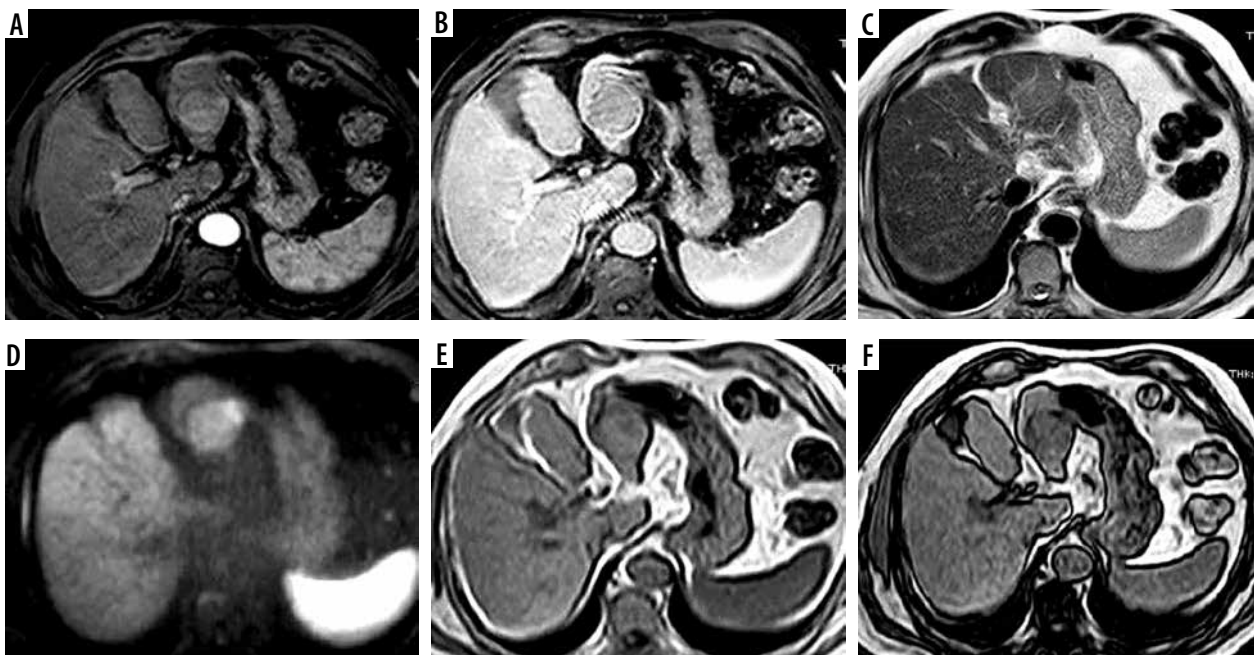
LR-5. A) Arterial phase shows a hepatic lesion in the left hepatic lobe with arterial hyperenhancement. B) The delayed phase shows washout with enhancing capsule. C) T2-weighted image shows an intermediate T2 signal. D) Diffusion-weighted imaging shows focal diffusion restriction. E, F) Foci of bright signal fat are seen in T1-weighted image (E) showing loss of signal in the out-of-phase image (F)
